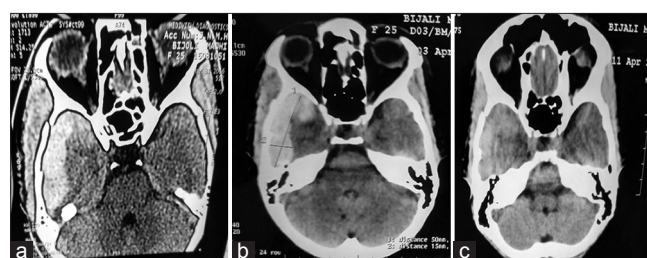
25 year female with right temporal EDH CT Scan shows a) initial CT scan at admission, b) Scan image after 5days of trauma, c) shows complete resolution of Right temporal EDH on 13th day of trauma, GCS of the patient remain stable during course of management
